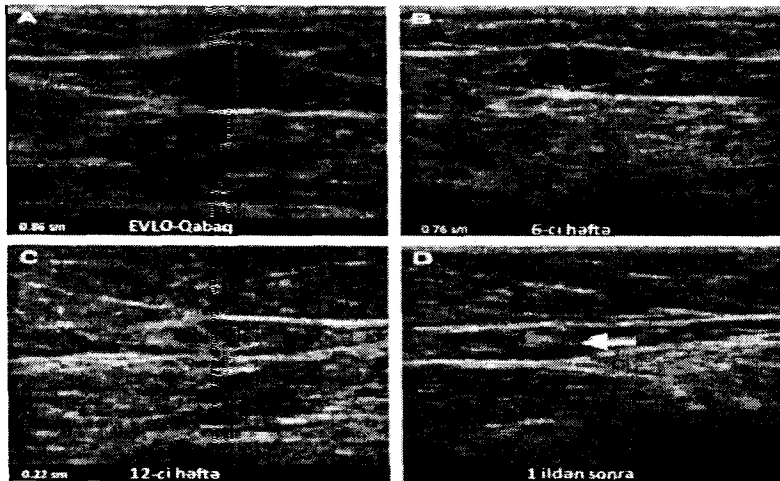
Dynamic observation of venous obliteration in patients with endavasal laser obliteration. Pre- and post-operational results at ultrasound dopler examination.
